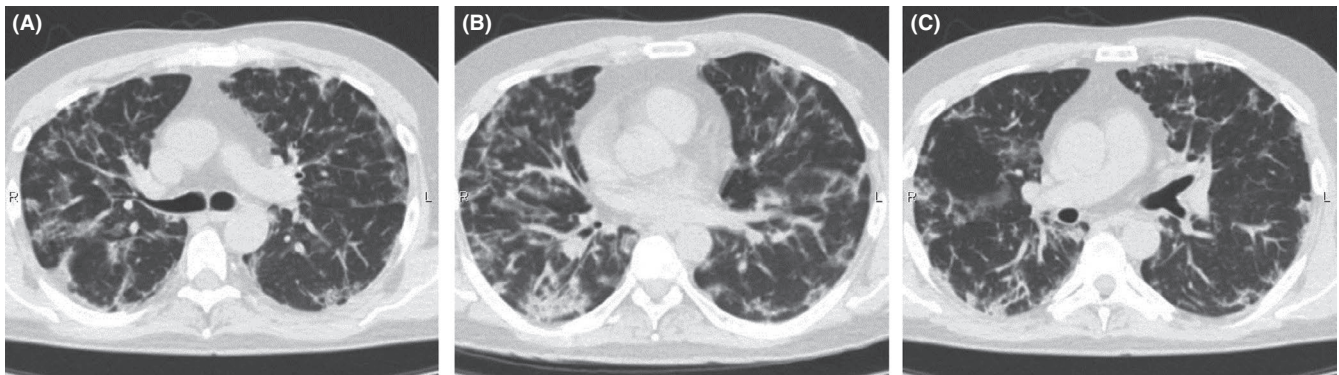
The CT scans show a further regression in the symptoms: the inflammatory spots are limited, there are interstitial changes, and presence of intense, bright linear shadows (interlobular thickening)
